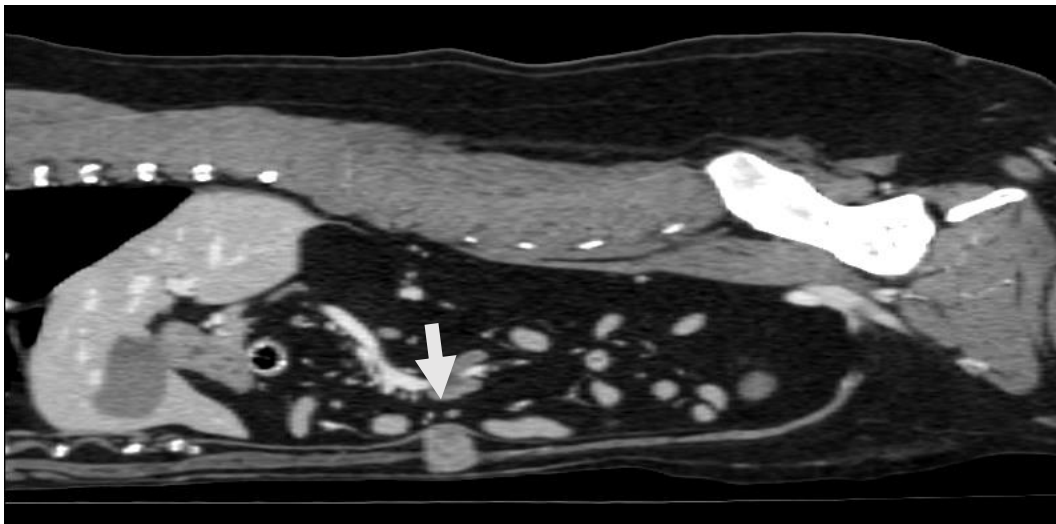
Post contrast sagittal CT reconstruction in soft tissue window. The soft tissue-attenuating nodule (white arrow) is located around 8 centimeters caudal to the liver.
